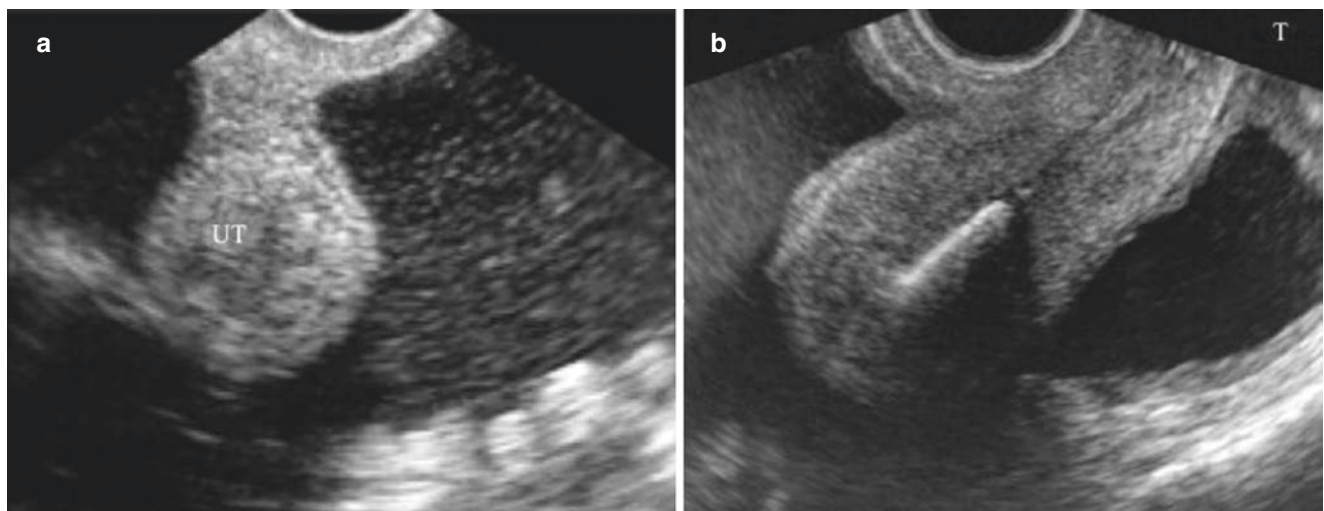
Ruptured ectopic pregnancy (EP with floating uterus). (a, b). After 37 and 43 days of amenorrhea, the patient under sudden lacerate pain at the lower abdomen. Ultrasound scan shows a lot of liquid areas
